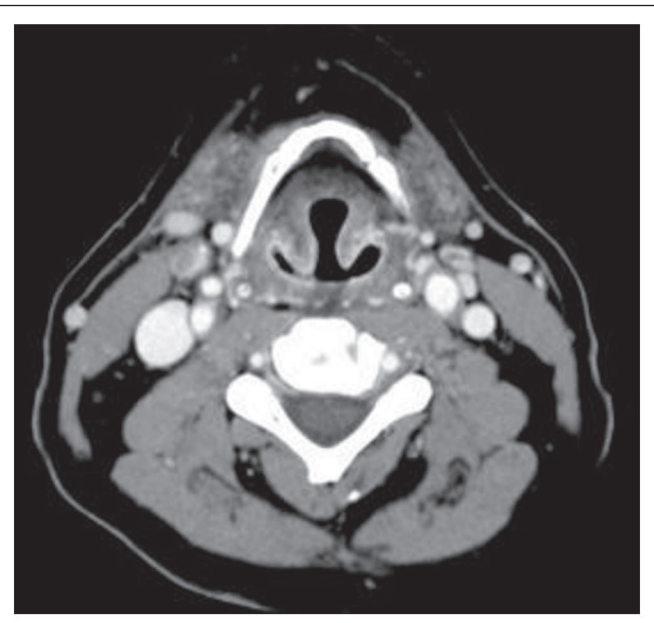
This 42-year-old patient received induction chemotherapy followed by radiotherapy (76.8 Gy at 1.2 Gy/fraction bid) for T3N2b tonsil cancer. Postradiotherapy computed tomography demonstrated a 1.1-cm node with definite calcification and probable focal lucency on the right and a fatty hilum on the left. Neck dissection was negative; the patient was controlled with 3 years of follow-up.
